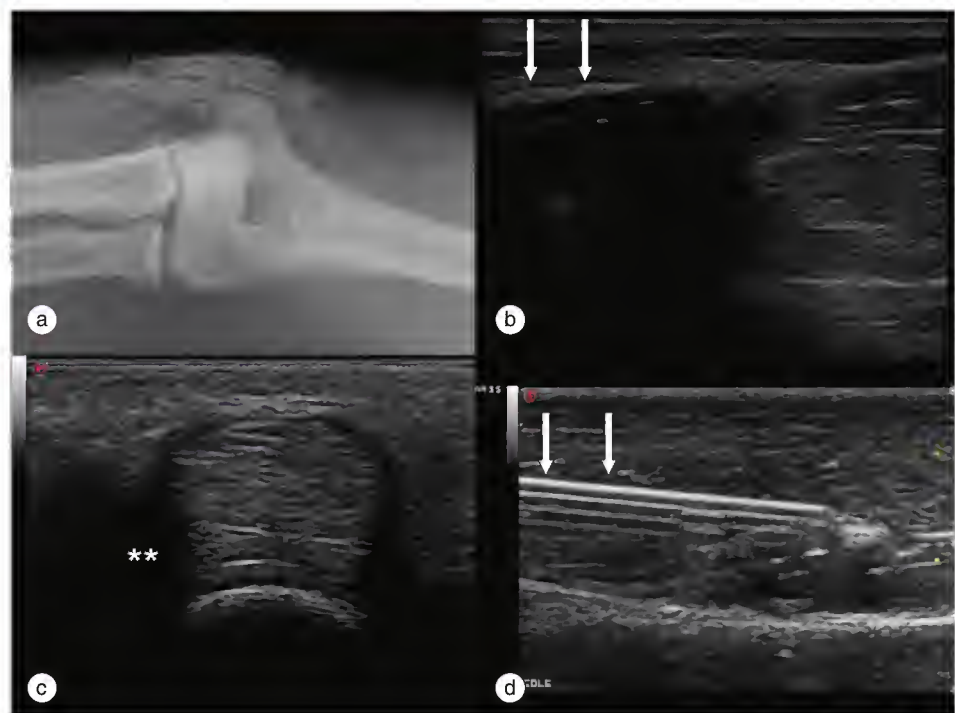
Common ultrasound artifacts. (a) Plain radiograph for a patient with systemic lupus erythematosus showing subcutaneous calcification on the ulnar aspect of the elbow. (b) The corresponding ultrasound image shows the edge of the area of calcification with hyperechoic calcified tissue (arrows) with acoustic shadowing deep to the calcified tissue on the left and normal skin, subcutaneous tissue, and muscle on the right-hand side. (c) Beam edge artifact caused by refractile shadowing at the side of a flexor tendon gives a hypoechoic appearance and can be mistaken for tendon sheath thickening or fluid. (d) “Comet tail” appearance of a needle in muscle tissue is a reverberation artifact.
